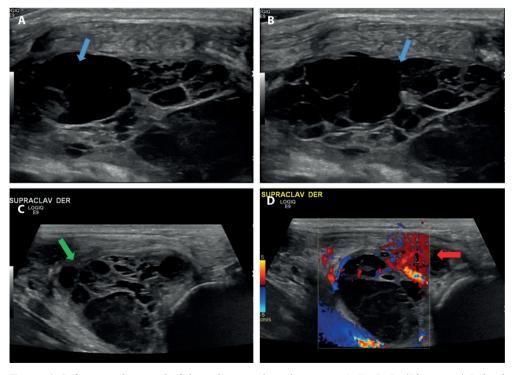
Soft-tissue ultrasound of the right supraclavicular region. A, B, C, D. (Blue arrow) Behind the right sternocleidomastoid muscle is a 5.8 x 2.8 cm multi-cystic lesion with multiple septations, filled with anechoic and heteroechoic content and (Red arrow) some vascular structures crossing it. Two other lateral smaller cysts, less than 9 mm in size, accompany the lesion. (Green arrow) There is another cystic lesion in the suprasternal region of 2.8 x 1cm.
